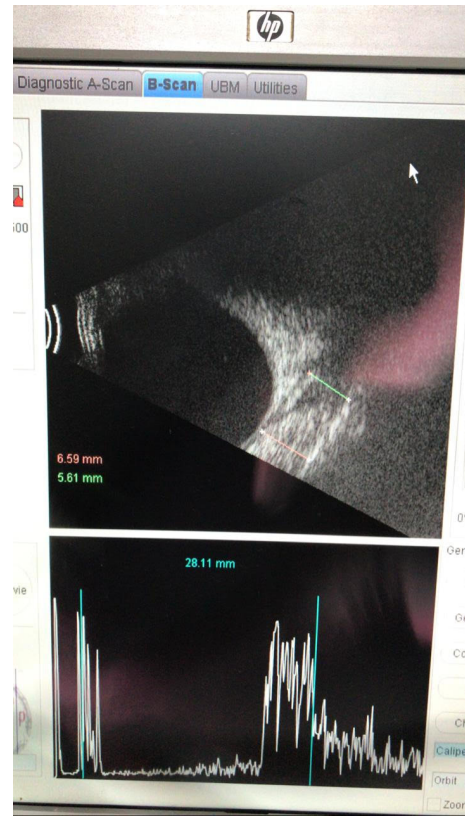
Ultrasonography b scan of the above patient showing a markedly thick inferior rectus belly with tendon sparing
